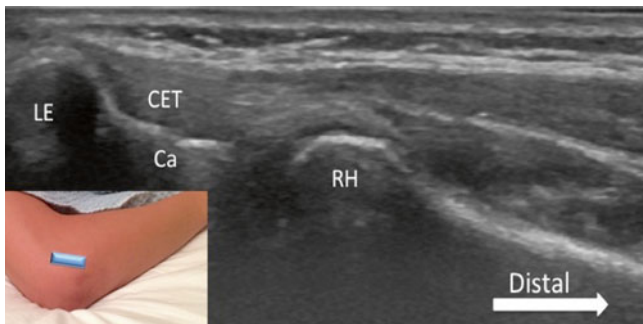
Sonogram of the common extensor tendon (CET) on its long axis. The position of the ultrasound probe is shown in the *inset*, with the cranial end of the probe placed on the lateral epicondyle (LE). The CET origin is seen as a continuous band of longitudinally oriented fibers. Ca capitellum, RH radial head (Reproduced with permission from Philip Peng Educational Series)
